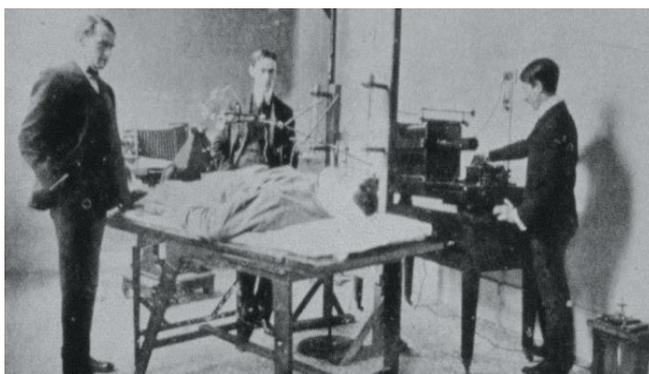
X-Ray Machine capturing Images from a patient (Image Courtesy: Johnson & Johnson Archives)
